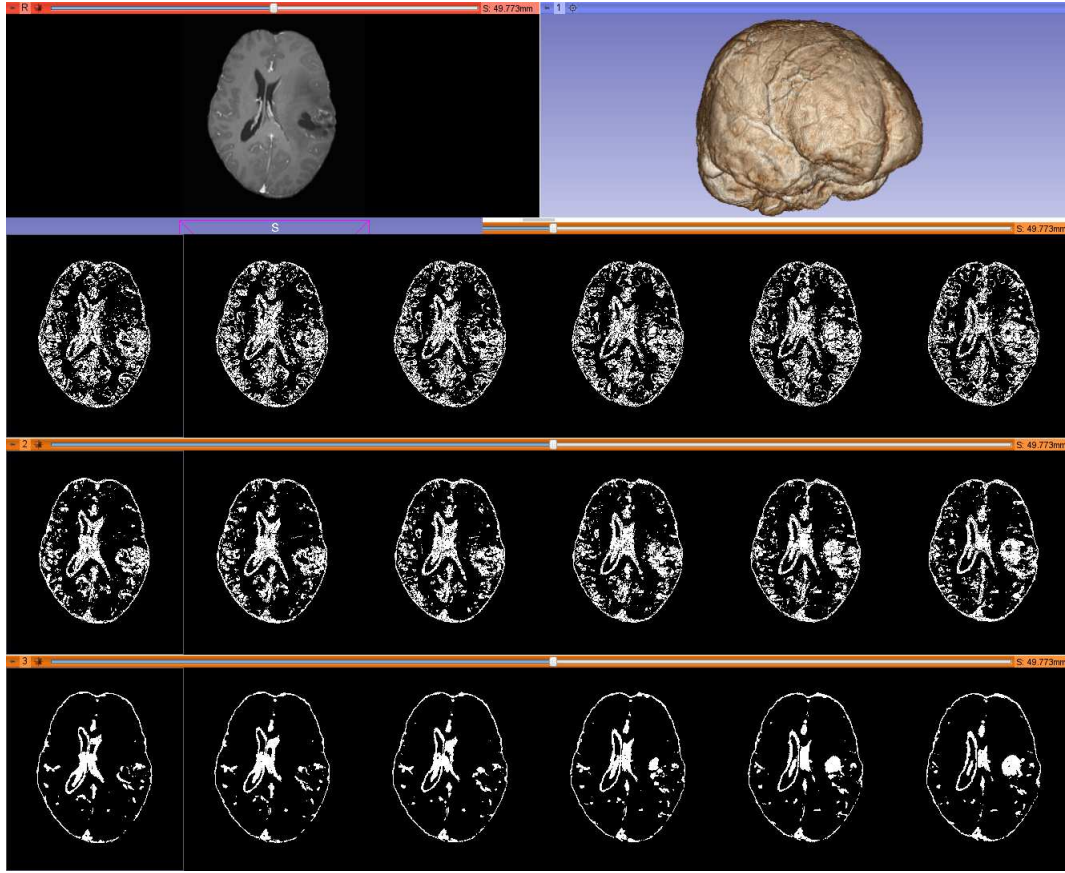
The distribution of the selected blocks in a brain MRI, using different non-connectivity patterns. The results are depicted on six consecutive MRI slices. From top to bottom row: axial pre-op MRI slice (left) and volumetric rendering (right), selected blocks with “vertex” non-connectivity, selected blocks with “edge” non-connectivity, selected blocks with “face” non-connectivity. The “vertex” pattern results in a more uniform distribution, while the “face” pattern results in a higher block density nearby the tissue boundaries/interfaces (i.e., intracranial brain, ventricles and tumor surfaces).
